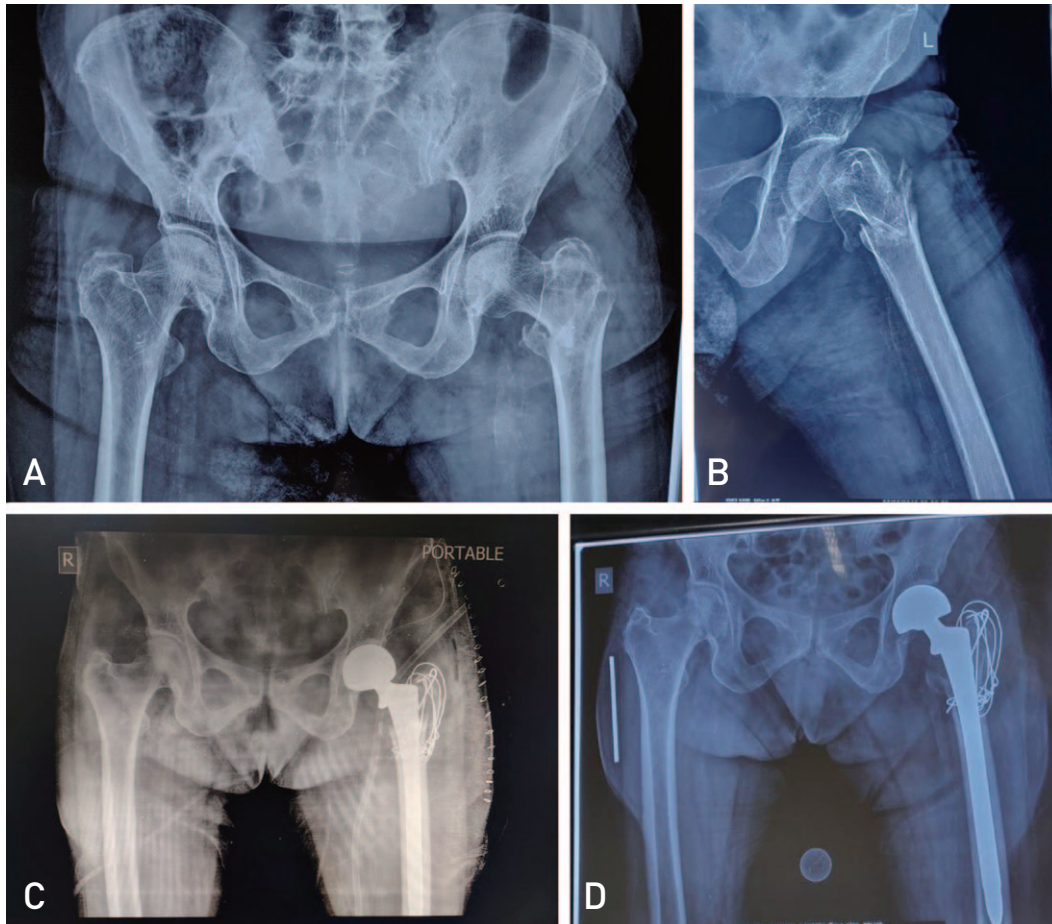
(A, B) Preoperative X-rays. (A) Pelvis with both hips - anteroposterior view. (B) Hip with femur lateral view. (C) Immediate postoperative X-ray hip with femur. (D) Follow-up X-ray. Pelvis with both hips - anteroposterior view showing union of the trochanter.
